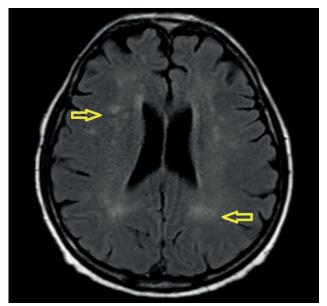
Bilateral high-signal foci in the periventricular and supraventricular white matter, some of which tended to coalesce in the subcortical area (arrows, FLAIR sequence MRI)
